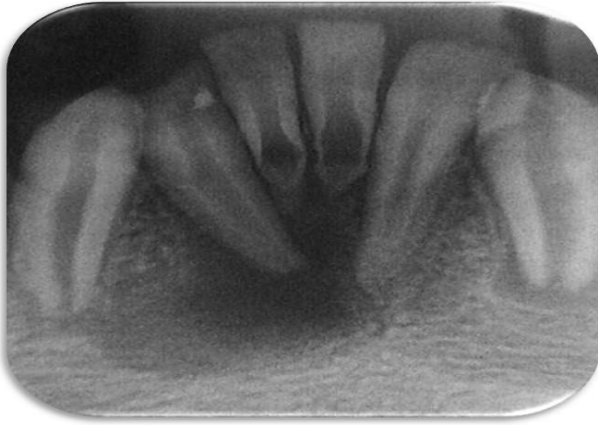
Initial radiography
